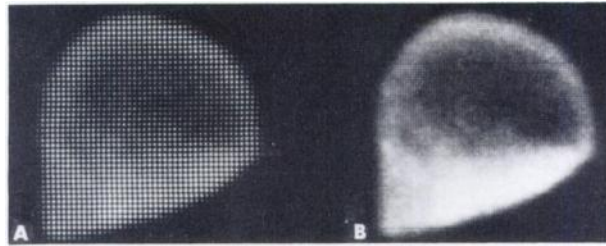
Comparison of same brain scintigram in two display modes—interpolated 128×128 (A) and 64×64 (B).
